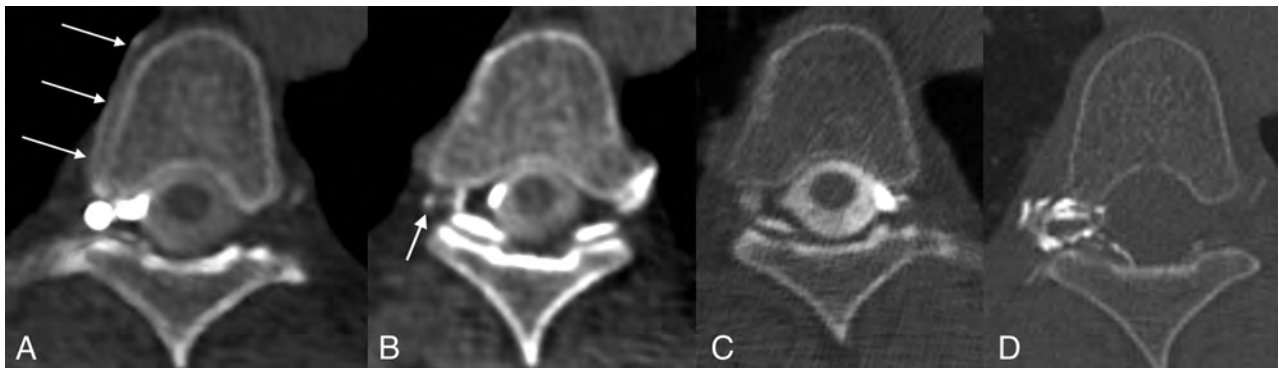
Right T5 CVF and subsequent treatment. *A*, Axial right lateral decubitus CTM image shows a right foraminal meningeal diverticulum and a hyperdense right paraspinal vein (*arrows*). *B*, Axial right lateral decubitus CTM image obtained immediately caudal to (*A*) shows opacification of a small radicular vein (*arrow*). *C*, Axial left lateral decubitus CTM image shows no abnormality. *D*, Axial posttreatment CT shows contrast-opacified fibrin sealant filling the foramen and extending into the epidural space of vertebral canal.
